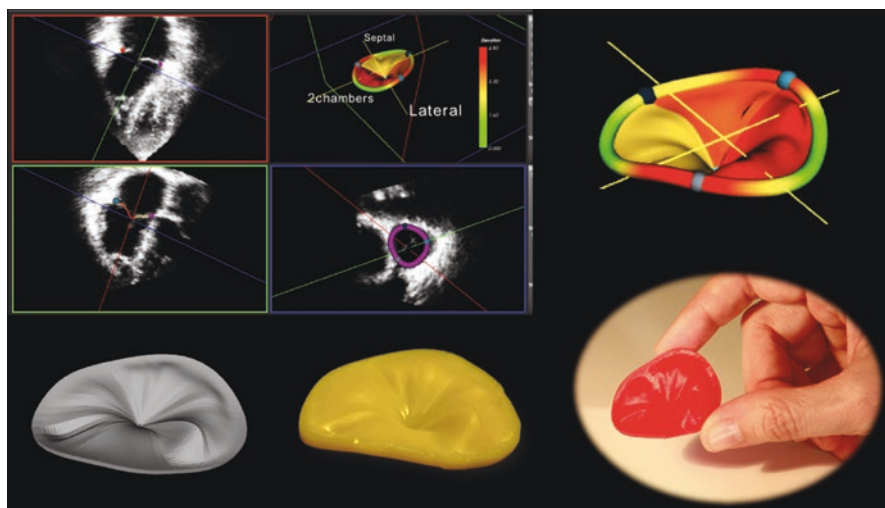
Segmentation of normal tricuspid valve from transthoracic 3D dataset by custom software (courtesy of Federico Veronesi, University of Bologna, Italy), that can be used to obtain a 3D printed solid model of the valve
